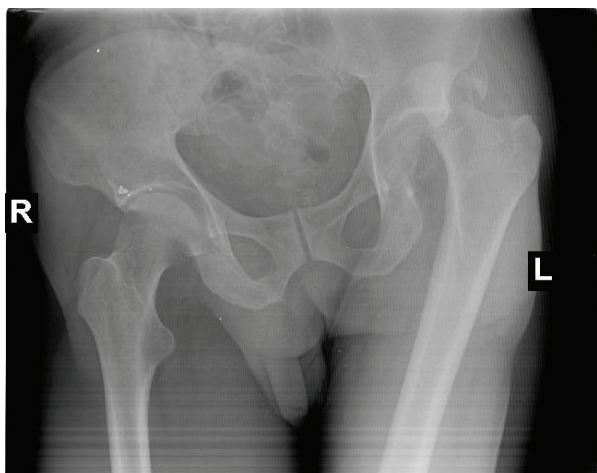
Antero-posterior pelvis radiography film: left hip fracture/dislocation of Pipkin type IV.
